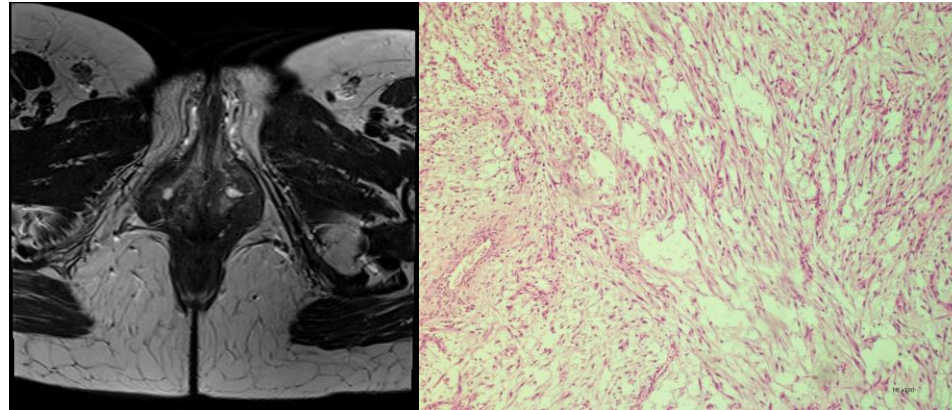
T2-weighted MRI with bilateral small Bartholin cysts and mild bulbospongiosus muscle hypertrophy
